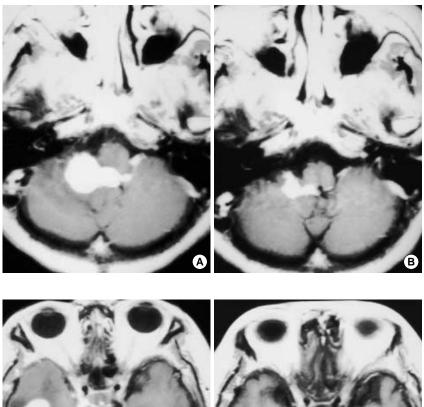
MRI at the first neurologic attack shows a homogenously enhancing lobulated mass extending to the fourth ventricle on gadolinium-enhanced T1-weighted axial image (A). The mass lesion almost disappeared after steroid treatment for 2 weeks (B).
